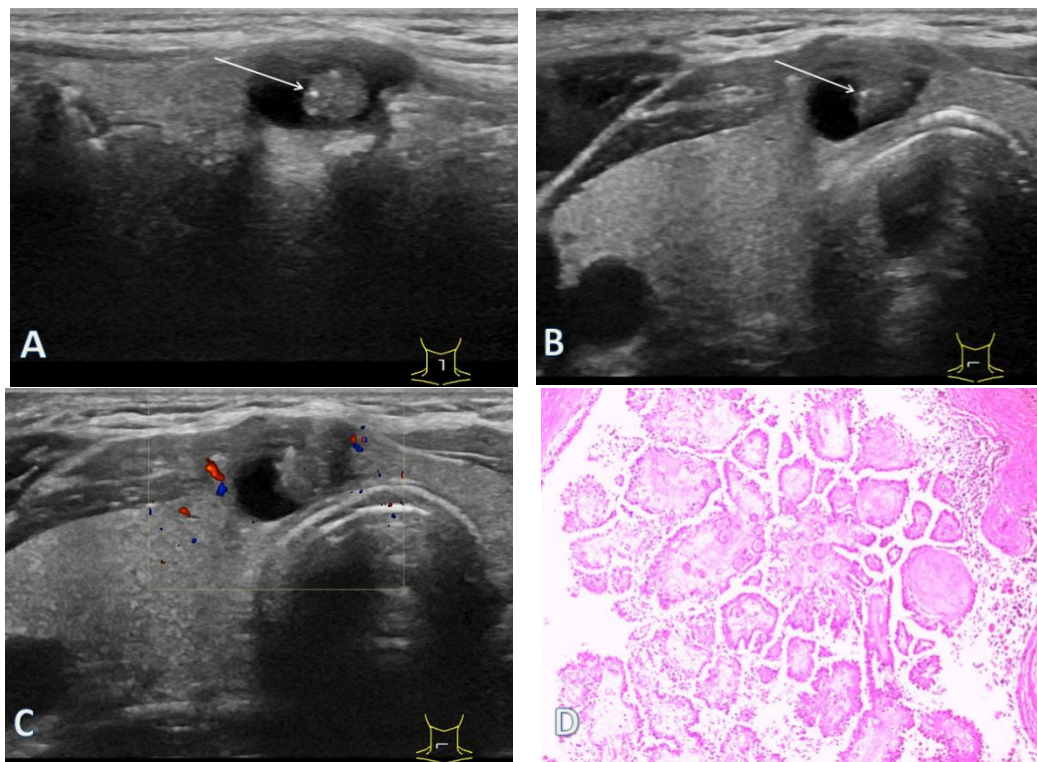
Ultrasonography of PTC combined with cystic degeneration in a 45-year-old male patient.
